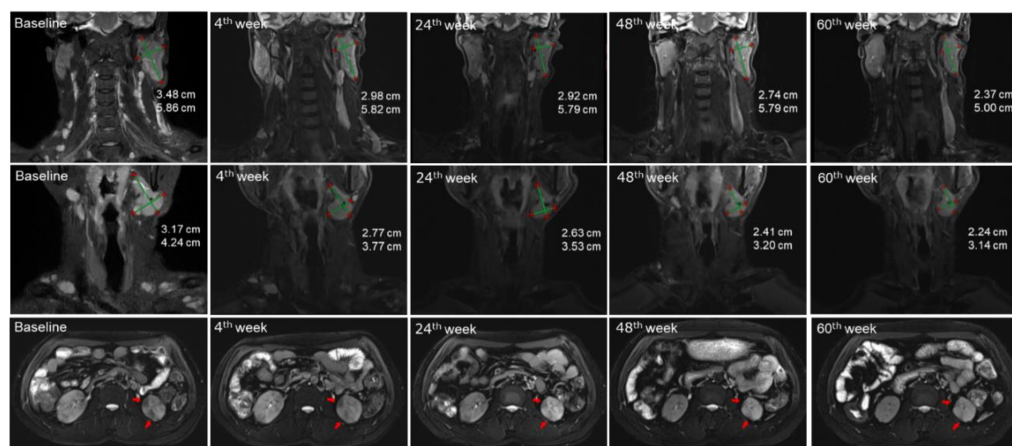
The maximum lesion area changes of multiple organs by MRI. The figure shows the maximum lesion area of left submandibular gland, bilateral parotid gland and lymph node in coronal plane, and the largest maximum lesion area of kidneys (red arrows) in transverse plane before (baseline) and after treatment with Telitacicept (at 4th, 24th, 48th and 60th week).
